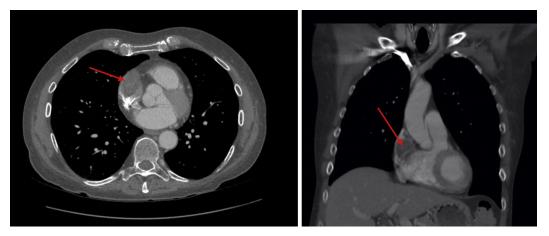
Chest CT scan, with axial orientation on the left and coronal on the right, demonstrating a hypodense homogenous mass in the right atrium (red arrows).
